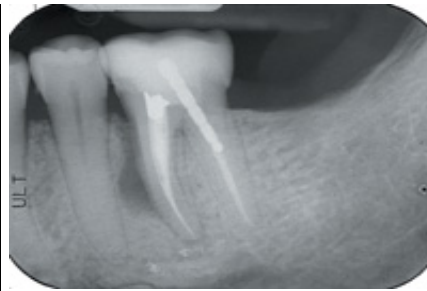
Pretreatment radiograph of mandibular first molar demonstrating a class III fracture.
